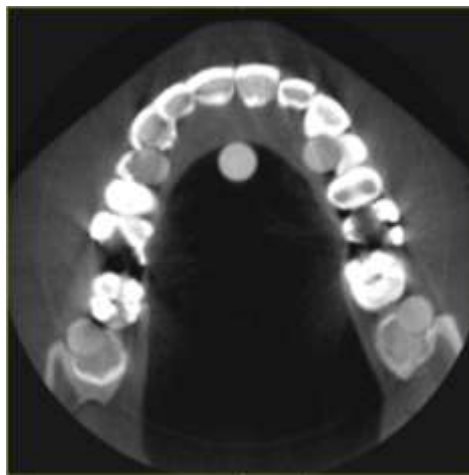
Picture for Single FOV CBCT protocol in field 14 cm x 8.5 cm. (Gendex Tomography GXCB 500).
